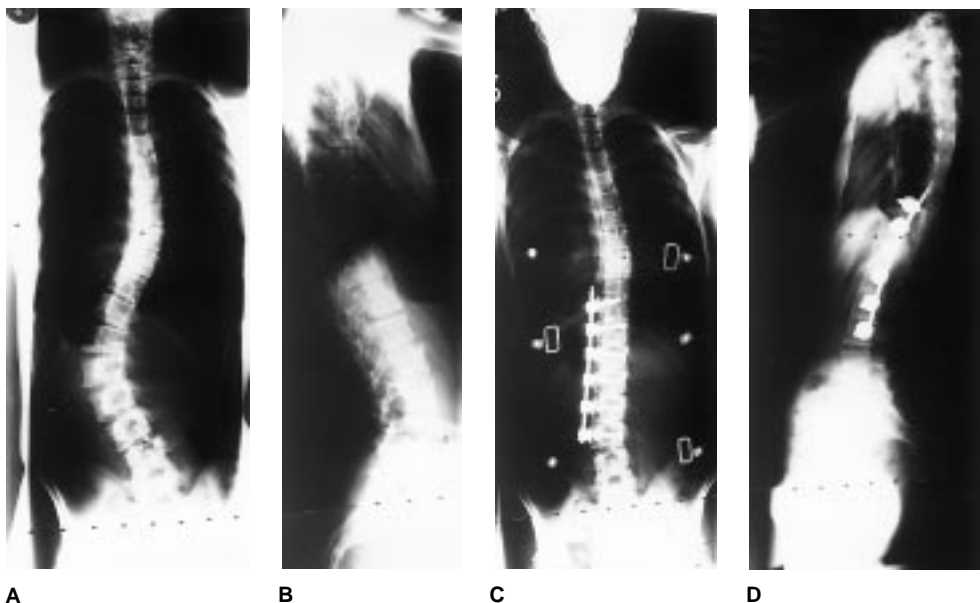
A and B, Preoperative radiographs of 14-year-old girl with 39-degree right thoracic curve and 60-degree left thoracolumbar curve. C and D, Postoperative radiographs of same patient at age 14 years 8 months, after anterior fusion with the TSRH anterior instrumentation, show a 24-degree right thoracic curve and a minimal residual thoracolumbar curve.
